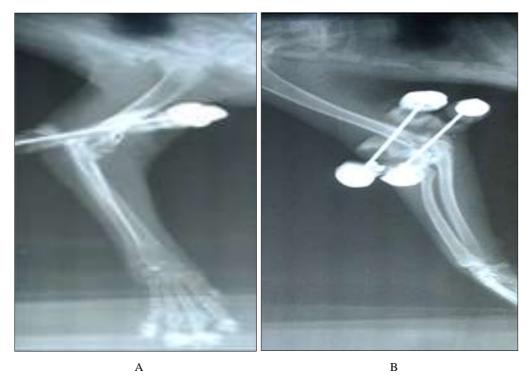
Postoperative radiograph anterio-posterior view (A) and lateral view (B) with corrected elbow joint
